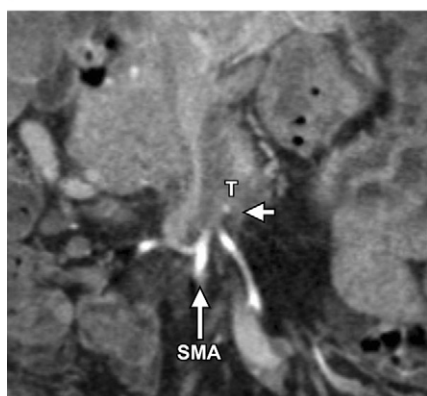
Images in a 60-year-old man with less than 180° of circumferential tumor contact with the SMA. (a) Axial contrast-enhanced biphasic multi-detector CT angiogram demonstrates a pancreatic body mass (T) directly contacting less than 180° of the SMA circumference without contour deformity (short arrow). (b) On the sagittal reformatted image, the length of tumor contact and vessel caliber are better delineated (short arrow). Finding less than 180° of tumor contact with the SMA places the patient in the borderline resectable category.
